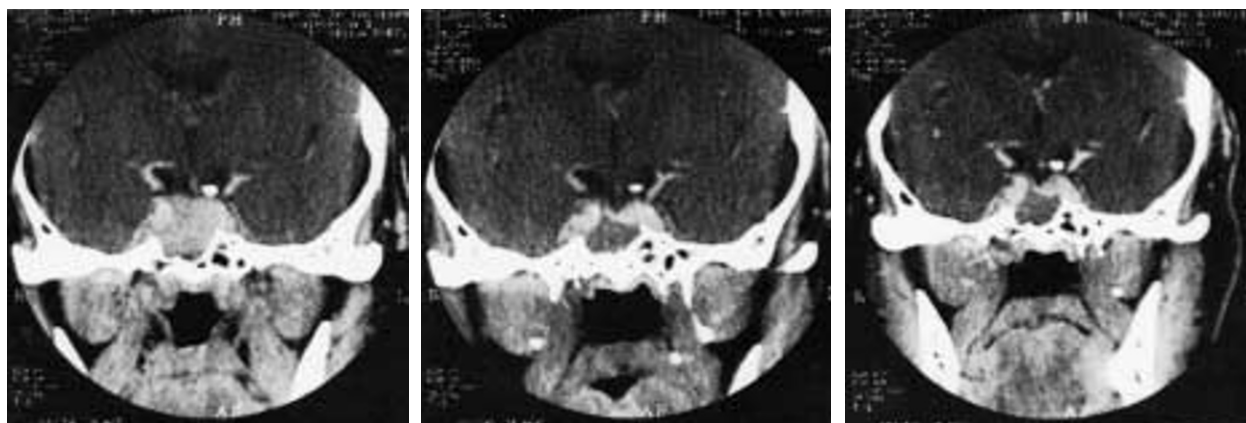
Neuroradiological findings of the pituitary macroadenoma on computed tomography scan; baseline and follow-up imaging after 12 and 24 months (left to right).
